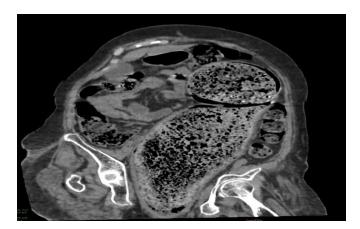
Coronal view of the abdominal CT of fecal impaction.
